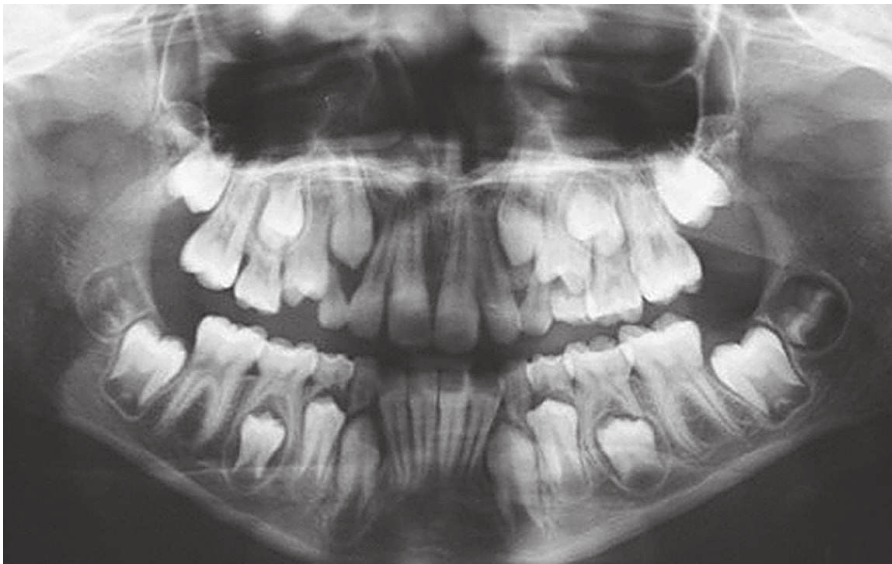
Second panoramic radiograph.
